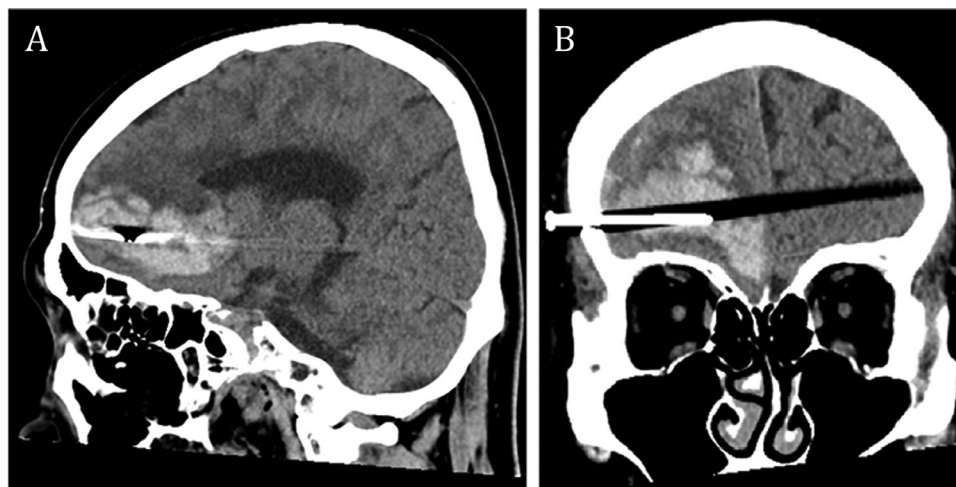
(A) Sagittal CT view of the head, revealing ICH in the right frontal lobe.
